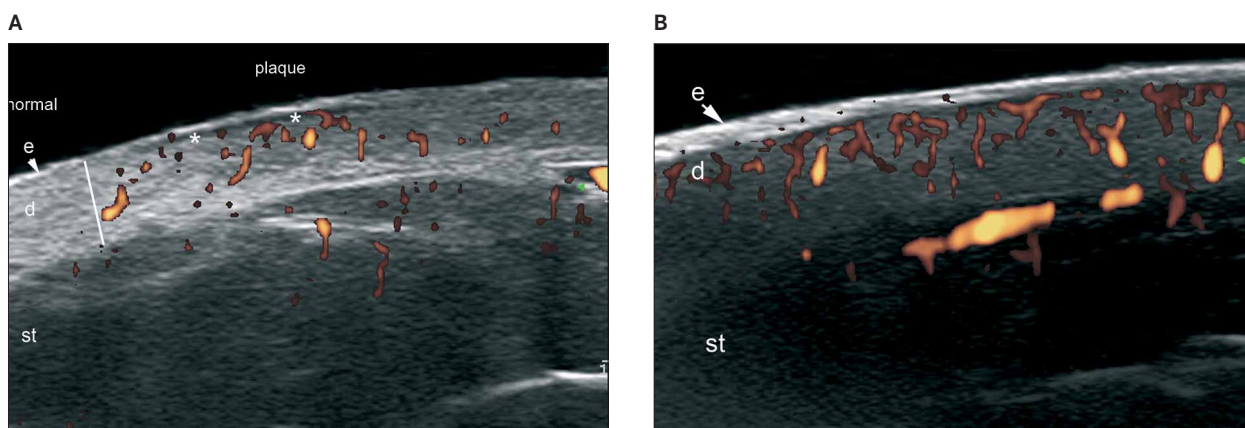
Psoriasis. A, Psoriatic plaque. Color (power) Doppler sonography (thoracoabdominal region, transverse view,) shows thickening of the epidermis and dermis in the psoriatic plaque. Decreased echogenicity of the upper dermis (asterisk) in the lesional area is also shown (in comparison with the normal skin on the left border of the image). There is increased blood flow within the dermal layer in the psoriatic plaque. B, Color (power) Doppler sonography (dorsal region, transverse view) in another case shows a substantial increase of the thickness of the epidermis and a highly vascular pattern within the psoriatic plaque. C, Color (power) Doppler sonography (right thumb, longitudinal view) in psoriatic onychopathy shows thickening of the nail bed and wavy nail plates. Increased vascularity is also shown within the nail bed. Abbreviations: d indicates dermis; dph, distal interphalangeal joint; e, epidermis; nb, nail bed; pl, nail plates; pnf, proximal nail fold; and st, subcutaneous tissue.
